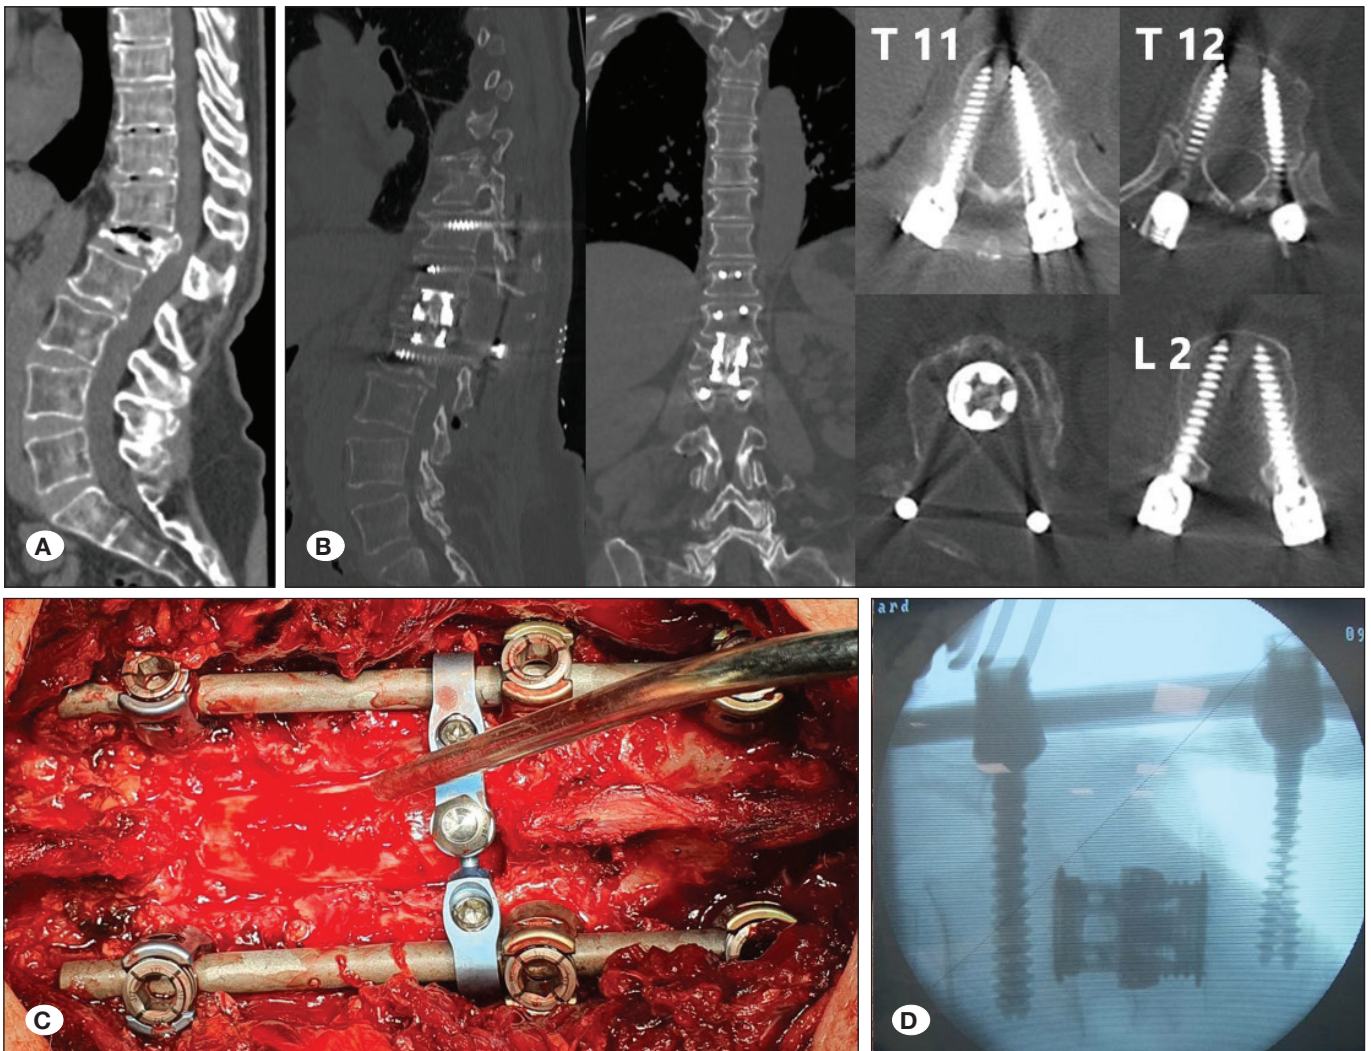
Case #8. A 75-year-old woman with severe L₁ compression fracture after MVA. A) Perioperative, and B) postoperative CT sections after L₁ posterior corpectomy and T₁₁-L₂ fusion. C) An intraoperative photo and D) fluoroscopy view showing the extent of posterior decompression and cage replacement.
